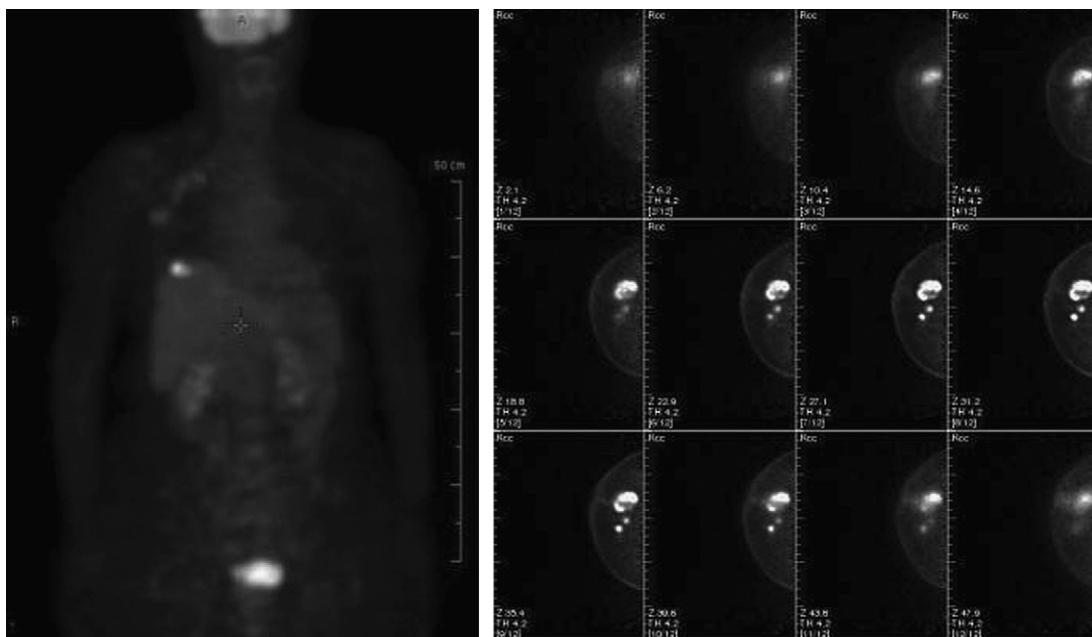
Comparison of a general purpose whole-body PET scan (left) with images obtained using an organ-specific dedicated high resolution PEM scanner (right) in a patient with breast cancer. A mass with increased FDG uptake is seen in the right breast. Clinical studies exhibit substantially higher spatial resolution and quantitative accuracy when using the dedicated PEM device. (Courtesy of Naviscan PET Systems, San Diego, CA.)
